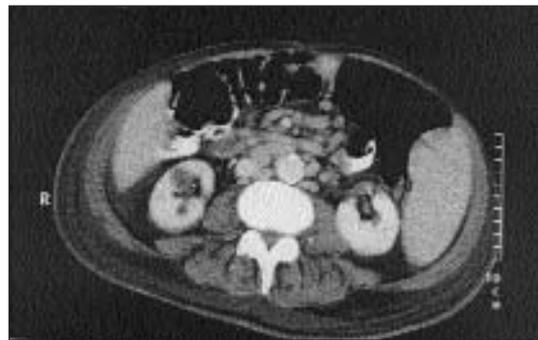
Splenomegaly, paraaortic, paracaval and postpancreatic lymphadenopathies on abdominal CT scan.
